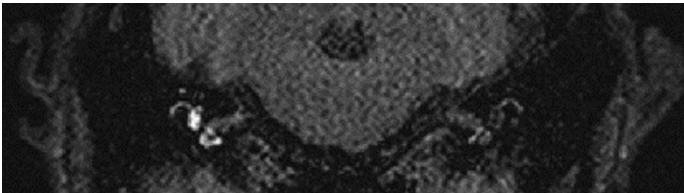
Axial 3D-FLAIR images 24 hours after gadolinium injection in the tympanum showing cochlear vestibular hydrops in the right inner ear. The 3 images are generated from same layer in the patient’s inner ear and the layer thickness is 1 mm.
